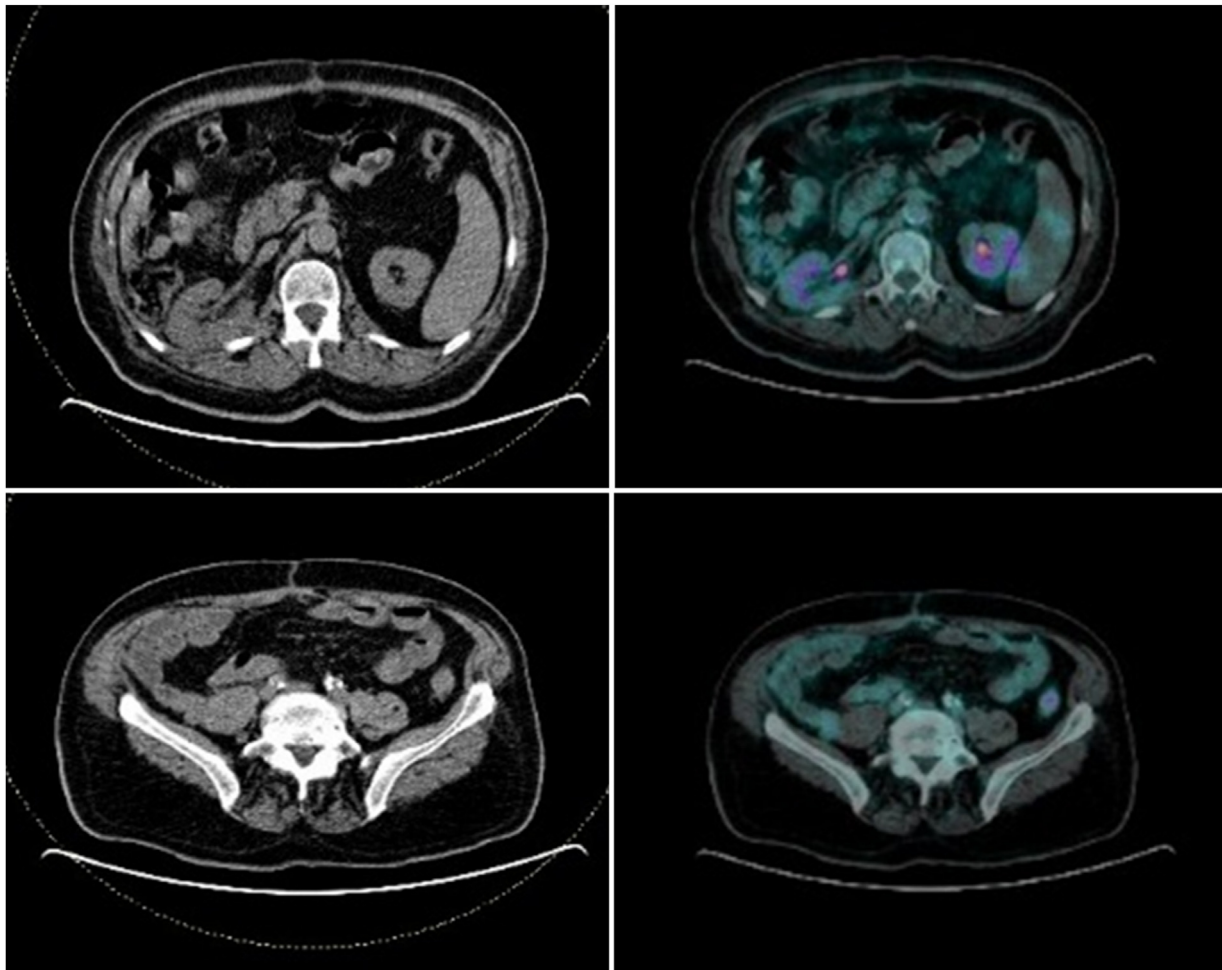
PET-CT Scan of the abdomen and pelvis: No FDG enhancement.
